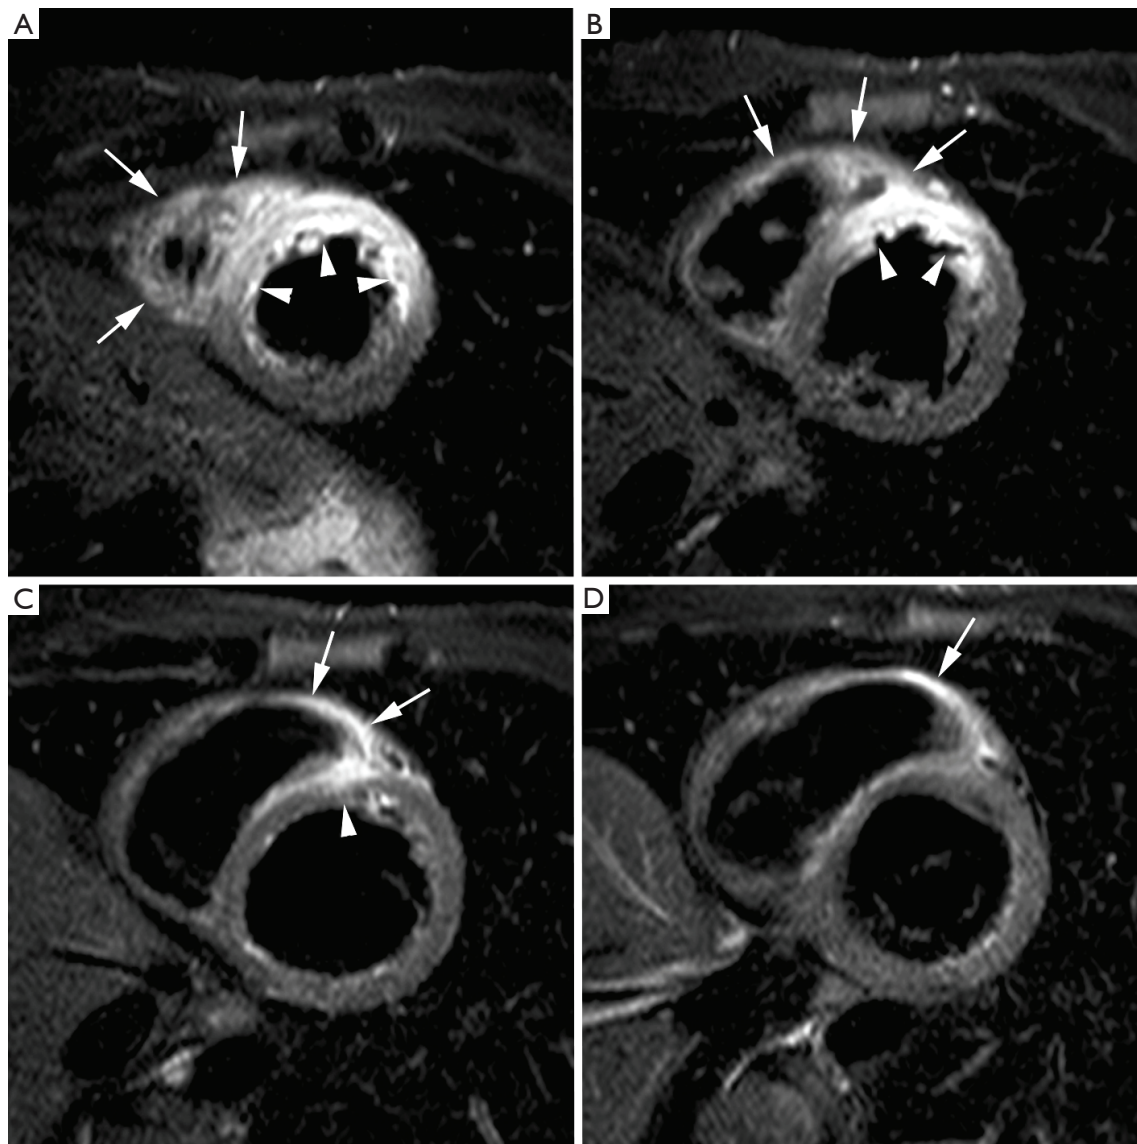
Edema imaging in a patient with a reperfused acute anteroseptal myocardial infarction (day 3 post MI). Short-axis T2-weighted STIR imaging at 4 levels (A-D). The jeopardized, edematous myocardium is visible as the myocardium showing increased signal intensity (*arrowheads*, A-C). Note the extension of the edema towards the adjacent RV anterior wall (*arrows*, A-D). Adapted from *Ischemic Heart Disease* by Bogaert J and Dymarkowski S, in *Clinical Cardiac MRI Second Edition*, Bogaert J, Dymarkowski S, Taylor AM, Muthurangu V (eds). Springer Heidelberg, Germany (ISBN 978-3-642-23034-9)
